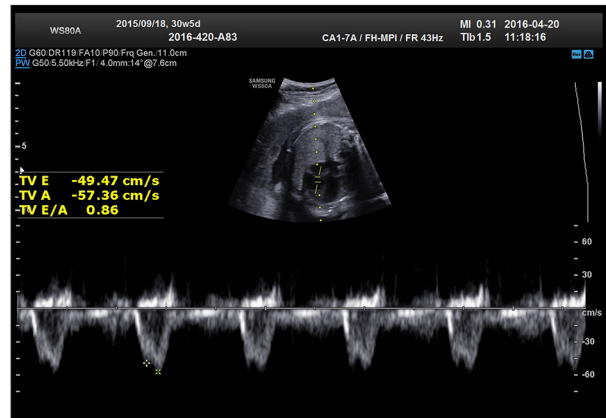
Ultrasound Doppler spectrum of fetal TV in the control group.
